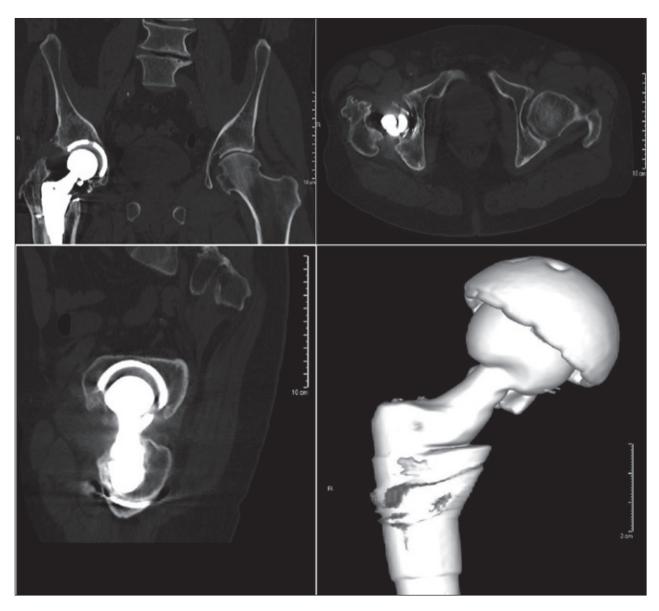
Computed Tomography scans demonstrating fragmentation of the ceramic femoral head
